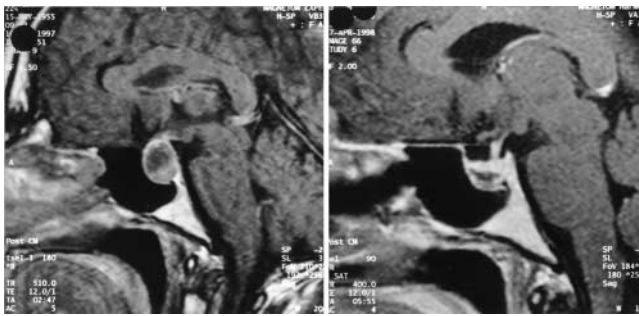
Sagittal T₁-weighted MR image obtained after intravenously administered Gd-DTPA in a patient with pituitary mesoadenoma (*left*). Sagittal MR image obtained 2 months postoperatively (*right*) demonstrating minimal contrast-enhancing scarring in the sphenoid sinus at the sellar floor, no detectable tumor, and a small intrasellar resection cavity.
